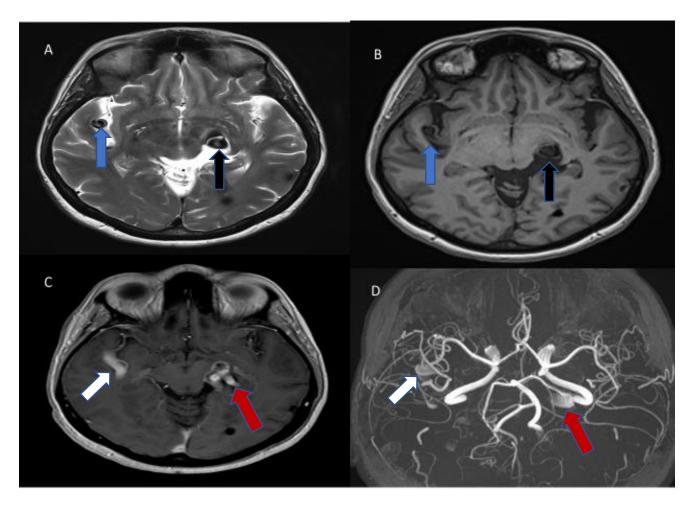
Axial images of MRI brain in T1W(A) and T2W(B) demonstrated signal void at the right sylvian fissure (black arrow) and left ambient cistern (blue arrow). There are also multiple blooming artefacts in SWI in keeping with calcifications as seen in previous CT scan. Figure 3C and 3D: MRA images demonstrated a large fusiform aneurysmal dilatation of M2 segment of right MCA within the right sylvian fissure (white arrow). There is also similar appearing fusiform aneurysm at the P2 segment of left PCA within the ambient cistern (red arrow). No evidence of thrombosis or restricted diffusion in DWI/ADC to suggest acute infarction.
